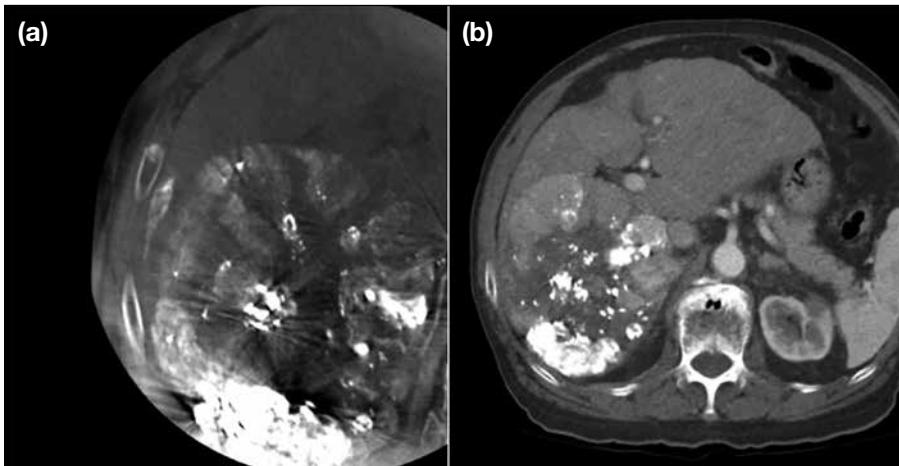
(a) Cone beam computed tomography (CBCT) of the liver in a patient with large right hepatic tumour after transarterial chemoembolisation (TACE). There are marked streaking artifacts obscuring assessment of the structures. (b) Angiography-computed tomography after TACE of the same patient. Compared to CBCT, it shows significant improvement of image quality with less streaking artifacts, fewer respiratory motion artifacts and wider field of view.
